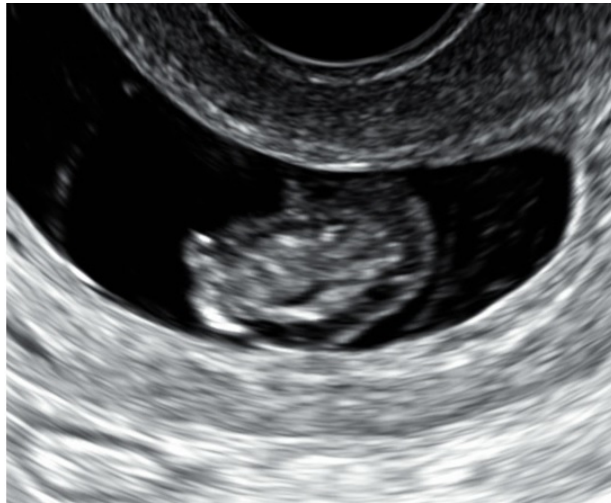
Fetal Hydrops First Trimester. Ultrasound (Sagittal plane).
